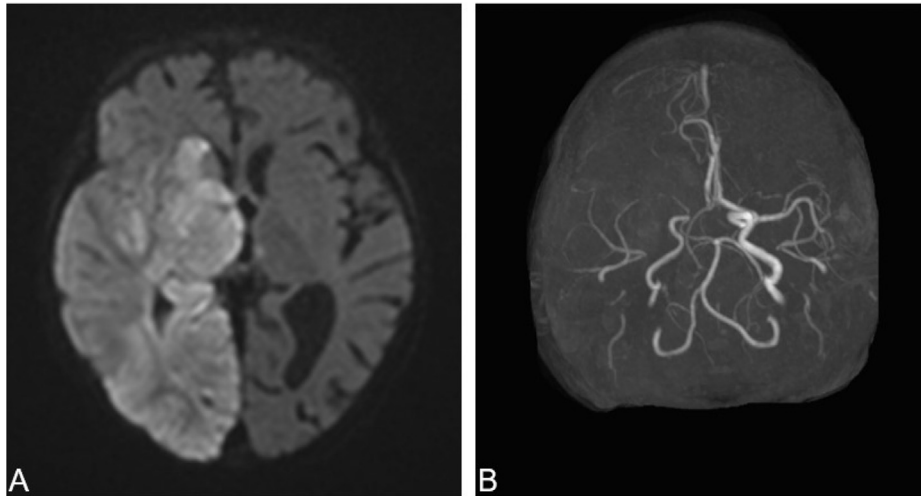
(A) Diffusion-weighted imaging magnetic resonance imaging demonstrating right middle cerebral artery, right posterior cerebral artery, and punctate left thalamic ischemic infarction. (B) Time-of-flight magnetic resonance angiography demonstrating occlusion of the proximal right middle cerebral artery and proximal right posterior cerebral artery.
